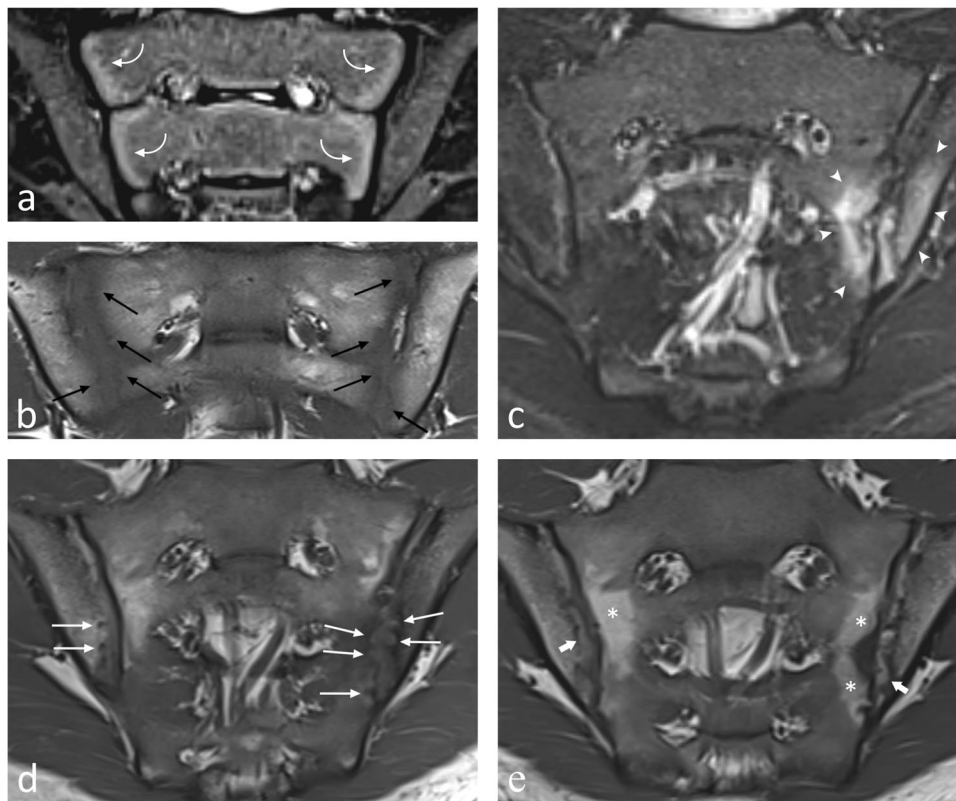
MR imaging examples of normal and pathological sacroiliac joint (SIJ) findings in pediatric patients. a Coronal oblique short tau inversion recovery (STIR) image of a normal 12-year-old boy showing normal variability with subchondral high signal (“flaring”) along the lateral apophyses of the sacrum (curved arrows). b Coronal oblique T1 image of a 14-year-old boy without back pain, sent for brain MRI because of headache and hypertension, showing normal variability with irregularities on both iliac and sacral side bilaterally (black arrows). c Coronal oblique STIR image of a 15-year-old boy with known spondyloarthritis and left-sided SIJ pain, showing active inflammation of the left SIJ with high signal in the joint space, bone marrow edema (arrowheads), and inflammation in erosion cavities on both iliac and sacral side of the left joint. d Corresponding coronal oblique T1-weighted image showing structural damage with erosions (long white arrows) and surrounding sclerosis on the iliac side of both SIJ and the left sacral side. e Coronal oblique T1-weighted image of the same patient, 5 months later, after treatment with etanercept showing bilateral periarticular fat metaplasia (asterisks), and areas of fat metaplasia in previous erosion cavities on the iliac side of both SIJ with surrounding sclerosis (“backfill”) (short arrows)
